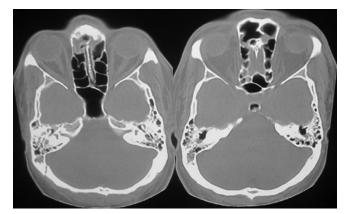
Non Contrast Computed Tomography scan of the temporal bone of the patient in the study showing bilateral opaque mastoid air cells and tympanic cavities
